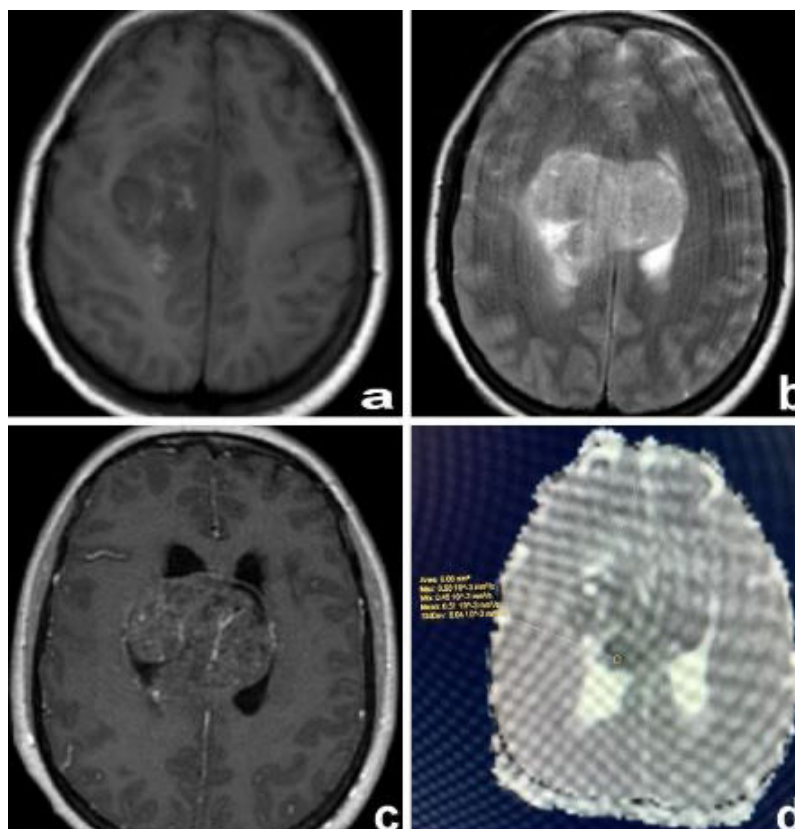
A 37-year-old female patient has a lesion located at the cingulate gyrus- corpus callosum region with a 57 mm diameter. On T1W images, hyperintense foci evaluated as hemorrhage are seen (a). It is observed that the lesion shifts and extends to the opposite hemisphere on contrast-enhanced T2W and T1W images, contains necrosis less than half of the tumor volume, has regular contours, shows little contrast, has little peritumoral edema, and is heterogeneous in both T1W and T2W (a, b, c). A total of score was 15 obtained from their morphological features. ADC value of 0.51×10^{-3} mm²/sec was obtained (d) from the areas showing tumoral enhancement. T1WI and T2WI = T1- and T2-weighted axial imaging, ADC = apparent diffusion coefficient.
